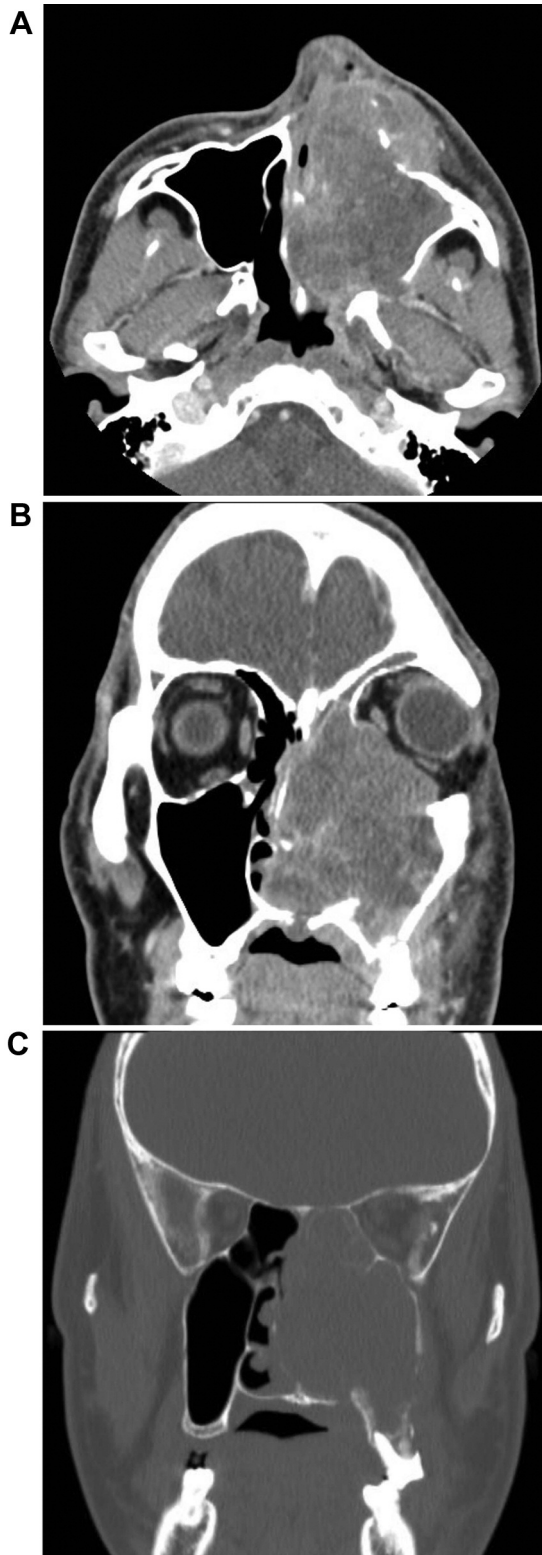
Sinus computed tomography at initial examination revealed a mass centered in the left maxillary sinus, with involvement of the ethmoidal and frontal sinuses. A: Axial plane. B: Coronal plane showing the soft-tissue condition. C: Coronal plane showing the bone condition.
